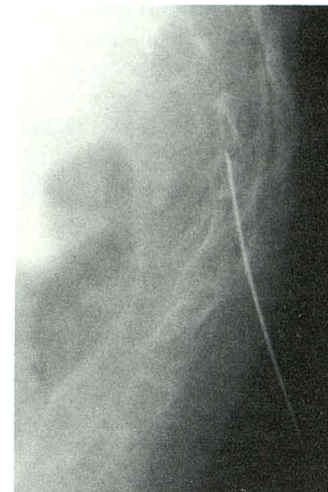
Radiograph shows intraosseous needle placement. In elderly, osteoporotic women, it is very easy to pass a 22-gauge needle through the cortex of the sacrum.
